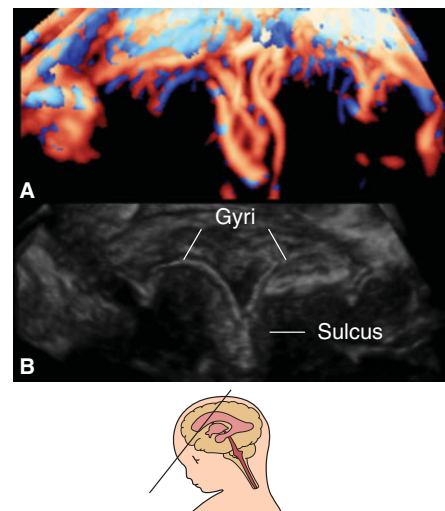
Coronal view of pial vascularity along the cerebral sulci and gyri by 3D bidirectional power Doppler angiography at 33 postmenstrual weeks of gestation. (A) 3D bidirectional power Doppler angiogram of pial vessels along the gyri and sulci. (B) 3D reconstructed image of the cerebral by surface γ gray scale. Protrusion of the brain surface due to gyral formation is demonstrated.
